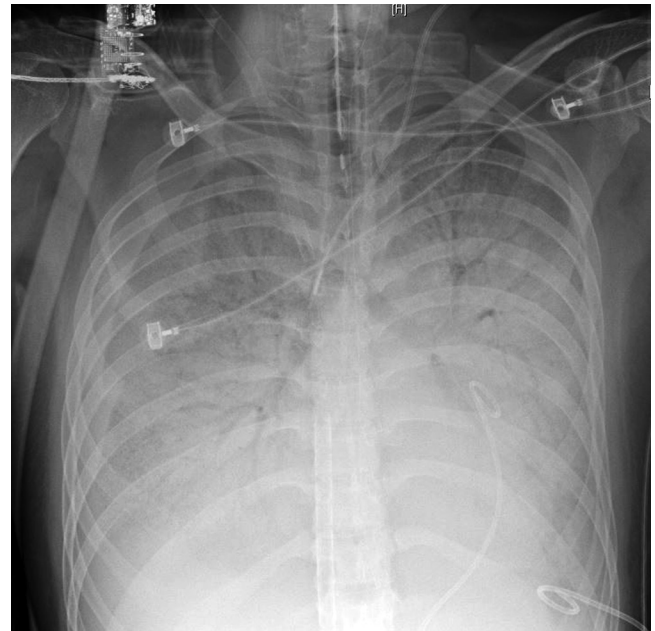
Chest x-ray of an adolescent boy admitted for severe adenoviral pneumonitis with acute respiratory distress syndrome requiring support with extracorporeal membrane oxygenation. The figure demonstrates extensive bilateral pulmonary infiltrates consistent with severe pneumonitis.
